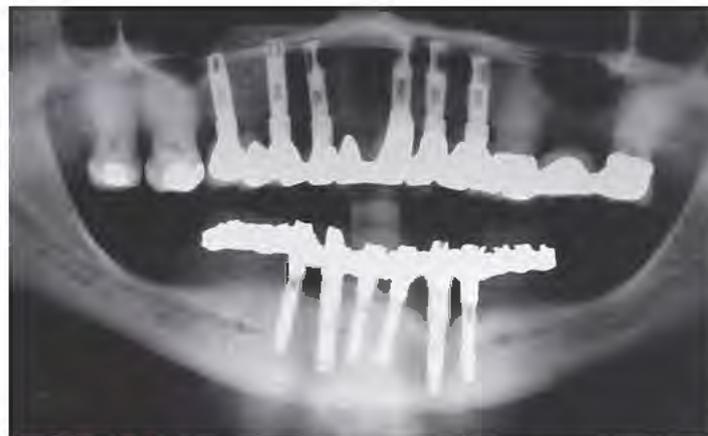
A panoramic radiograph showing a mixed tooth- and implant-supported, fixed, cementable, porcelain fused to metal prosthesis in the maxilla and an implant-supported, fixed-detachable hybrid mandibular prosthesis.
